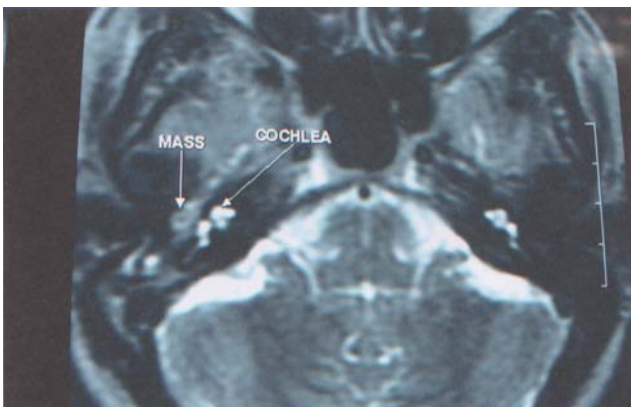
MRI of temporal bone showing circumscribed enhancing space occupying lesion in medial aspect of right middle ear along the cochlear promontory suggestive of glomus tympanicum without any evidence of extension into jugular fossa and carotid canal
